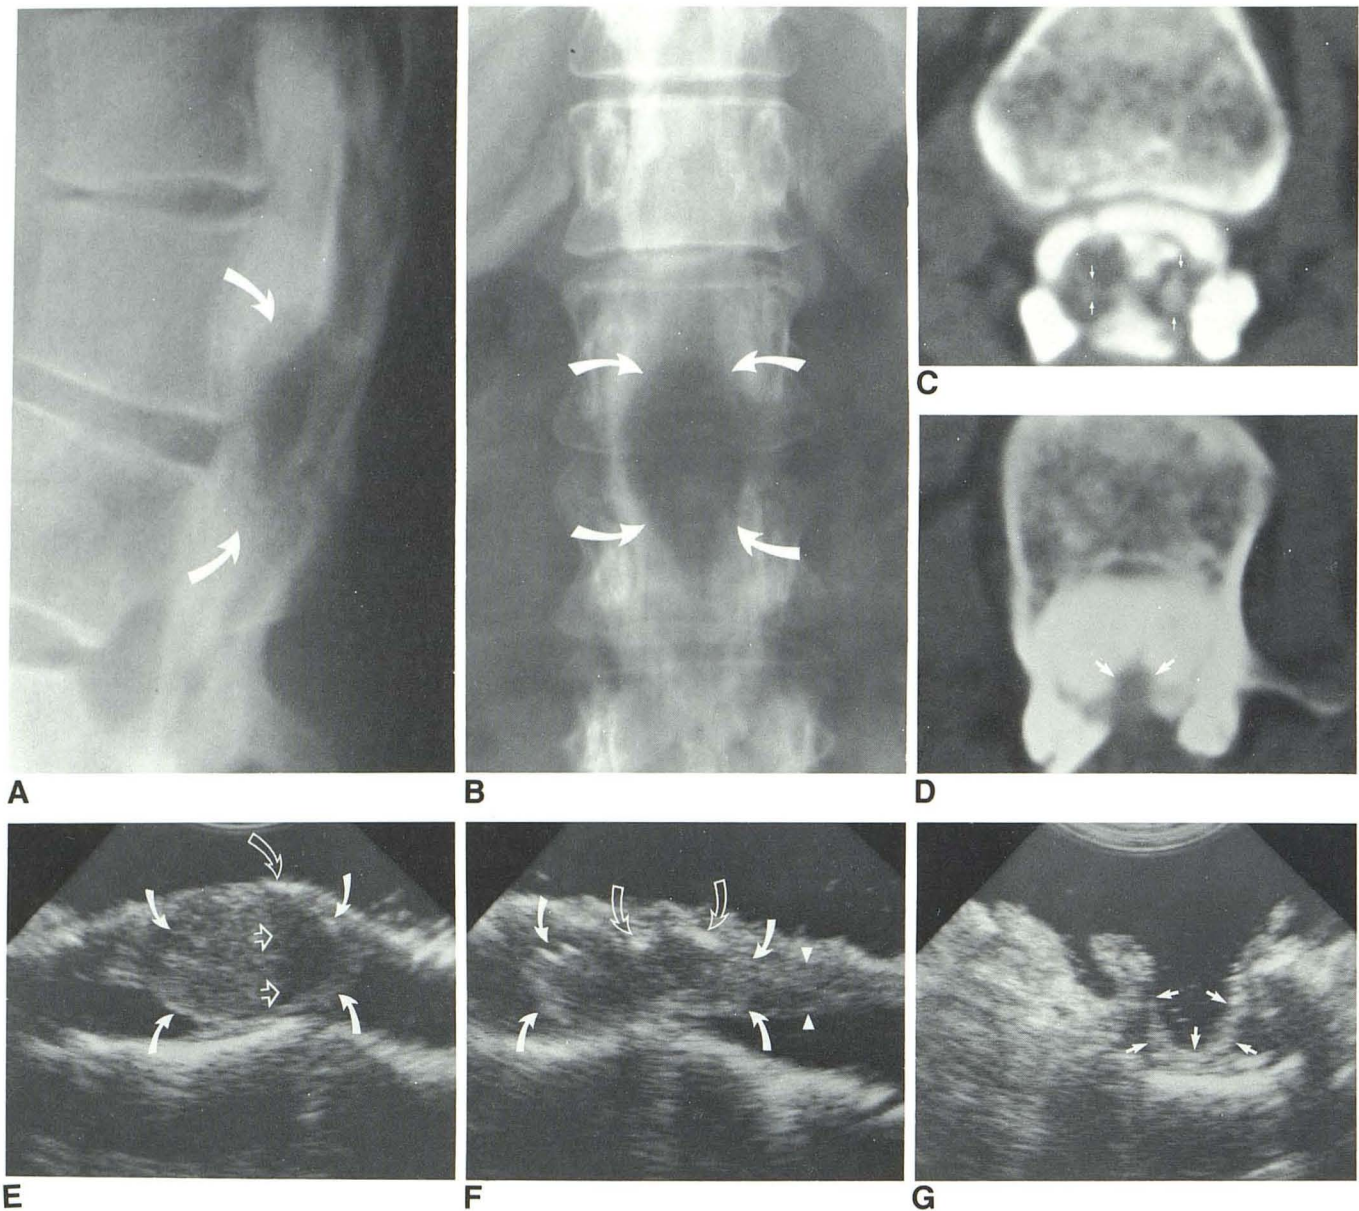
36-year-old patient had three previous operations (19, 9, and 5 years ago) for attempted removal of dermoid tumor of lower thoracic cord. Because of increasing incontinence and paraplegia water-soluble-contrast myelography (A and B) and metrizamide CT (C and D) were performed. A and B, At L1–L2, radiopaque contrast caps a mass (arrows) at level of conus medullaris. C, Metrizamide CT at L1–L2 level shows irregular mass within which there were areas of increased density (arrows). We were uncertain whether increased densities represent calcium or metrizamide that had penetrated into interstices of tumor. D, 1 cm below C at mid L2 level. Normal-appearing tip of conus (arrows). On these studies it was difficult to determine anatomic plane that separated tumor from normal spinal cord tissue. E, Initial longitudinal IOSS to right of midline. A well circumscribed mass (solid curved arrows) corresponded to oval mass in right side of canal in C. Bright reflecting echo on
